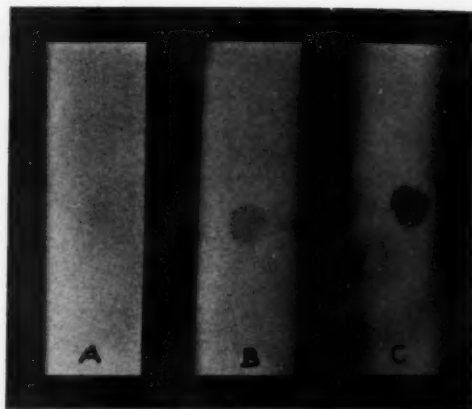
Penrose drain containing barium and a paraffin pellet radiographed at 85 kv. (A), 100 kv. (B), and 120 kv. (C). Note increase in transparency of barium with increase of voltage.
